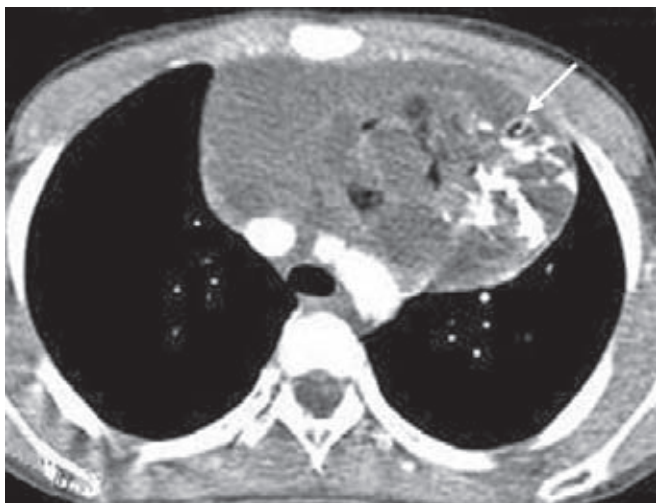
CT scan in another patient with stridor shows a calcified anterior mediastinal mass (white arrow). The low attenuation areas within the mass represent fat
